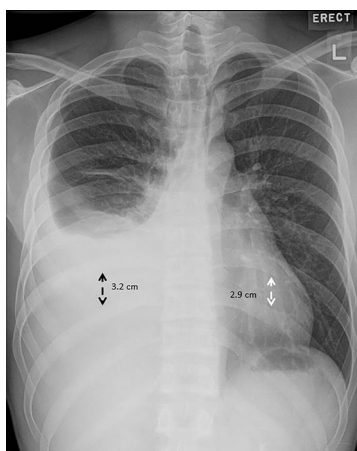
Chest radiograph showing a right pleural effusion, with subtle widening of the distance between the right 9th and 10th ribs compared to the left. The distances were measured on a radiology imaging workstation.
